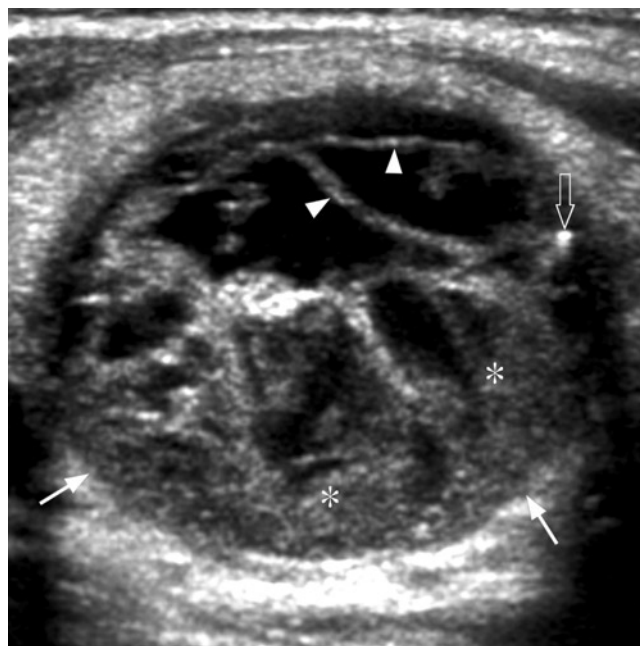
Transverse GS US shows a heterogenous cystic nodule (*arrows*) with intranodular septa (*arrowheads*), debris (*asterisks*), and comet tail artifact (*open arrow*) suggestive of colloid nodule. The debris is usually avascular on Doppler and is suggests of intranodular hemorrhage
